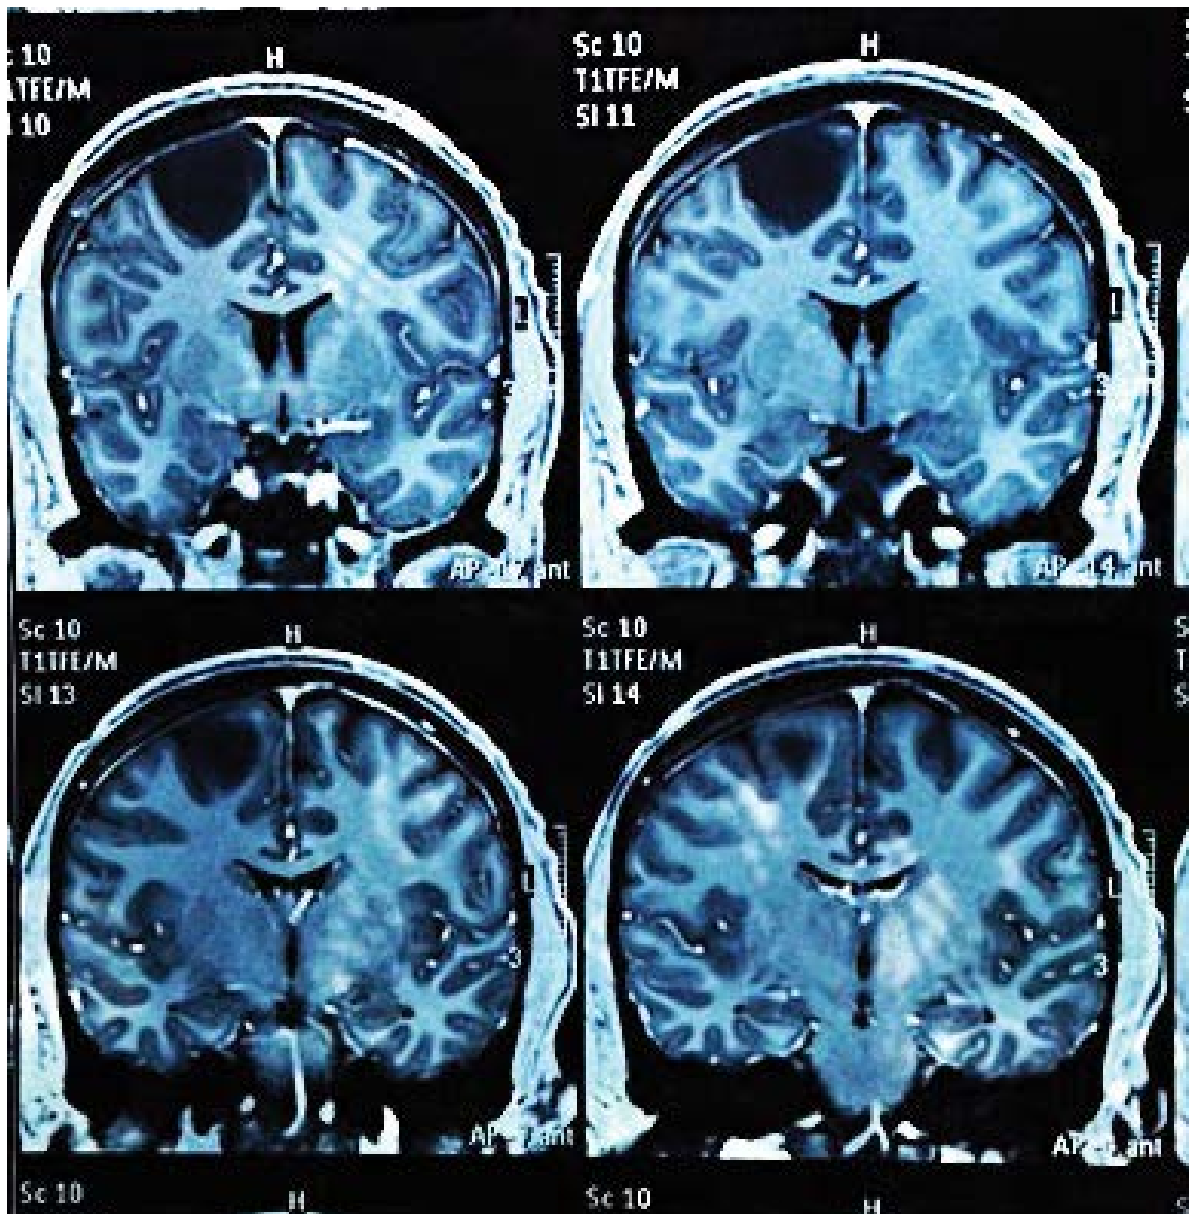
Postsurgical MRI. Frontal tumor resection of 95% is seen.
